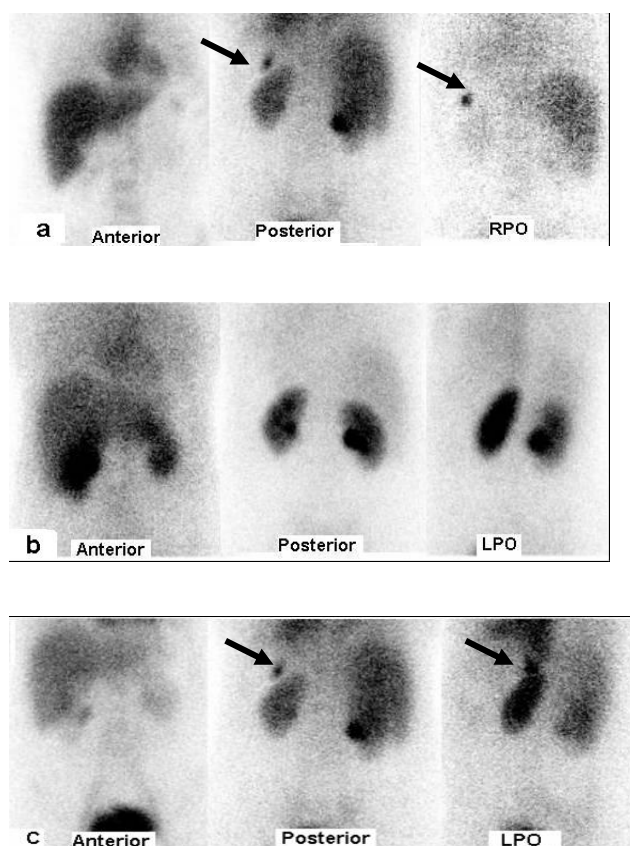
Accessory spleen was localized preoperatively (a). At the day of the operation control scintigraphy did not visualize any focus of uptake (b). After IVIG administration was stopped for 3 days, the accessory spleen was demonstrated again at the same area (c).
